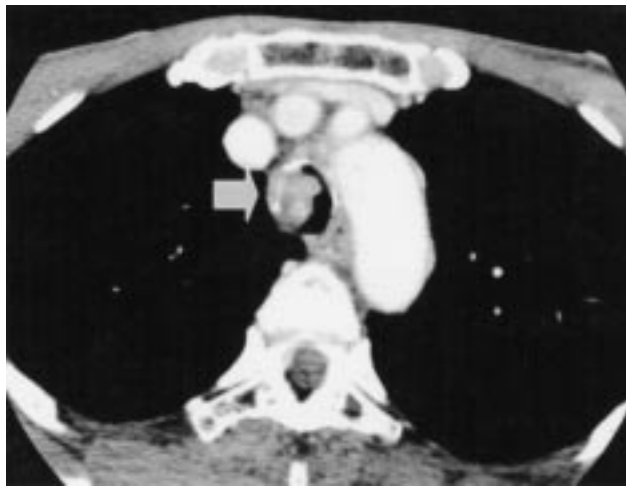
Chest enhanced computed tomography showed an almost completely obstructive tracheal tumor with a heterogeneous enhancement. Mediastinal lymph node swelling was not detected.
